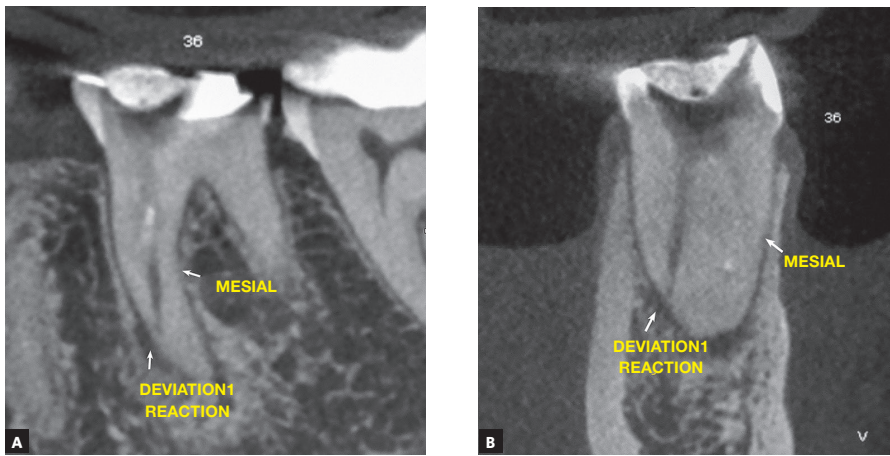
A) Computed tomography showing root canal deviation and perforation. B) Perforation of the mesiolingual canal
